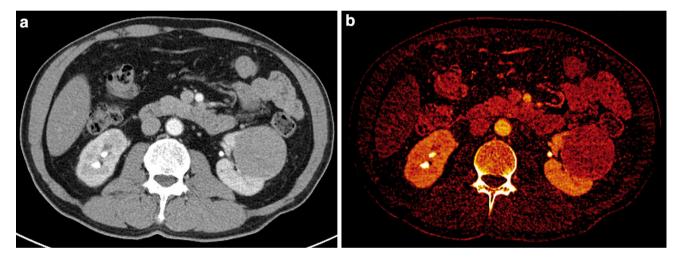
A 60-year-old male was evaluated for hematuria. a A sizeable well-defined hyperdense cystic lesion is seen in the left kidney on triple-bolus contrast CT scan. b The 'iodine overlay' image shows iodine uptake, indicating presence of enhancement. Comparison between true unenhanced (not shown) and post-contrast images
